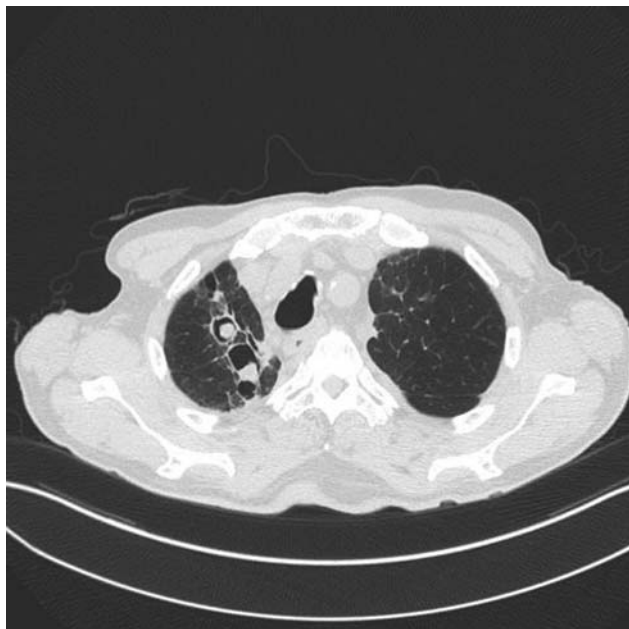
Computed tomography of the chest demonstrating a right upper lobe cavity with internal debris and surrounding ground glass and consolidation consistent with a mycetoma.
